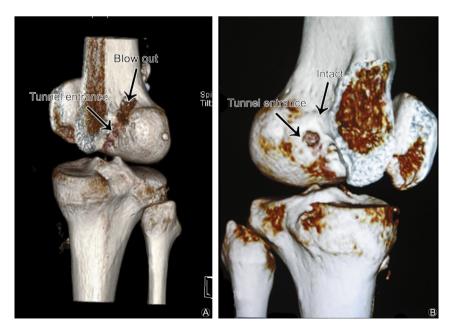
Three-dimensional reconstructions of CT scan. (A) Partial blowout in posterior wall in the femoral tunnel. (B) Intact posterior wall of the femoral tunnel.
